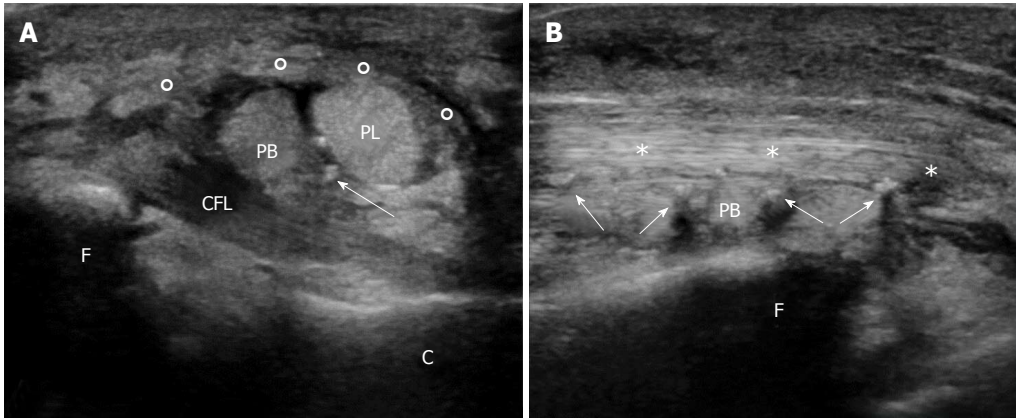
Ultrasound and magnetic resonance imaging evaluation of the injured ankle. A: US examination of the injured ankle: Avulsed retinaculum (°); two hemi-tendons due to split lesion of peroneus brevis (\*); CFL (arrow). B: MRI T2w axial sequence: MRI shows PB anterior subluxation. The avulsion of the retinaculum (arrow) can be observed. US: Ultrasound; MRI: Magnetic resonance imaging; PB: Peroneus brevis; PL: Peroneus longus.
